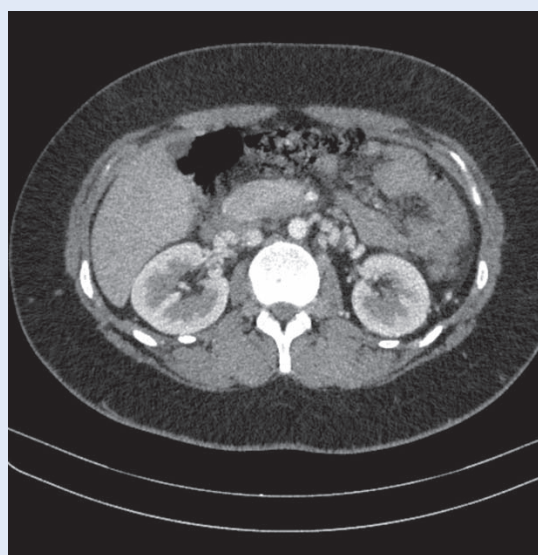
Axial abdominal CT scan – Absence of IVC.
